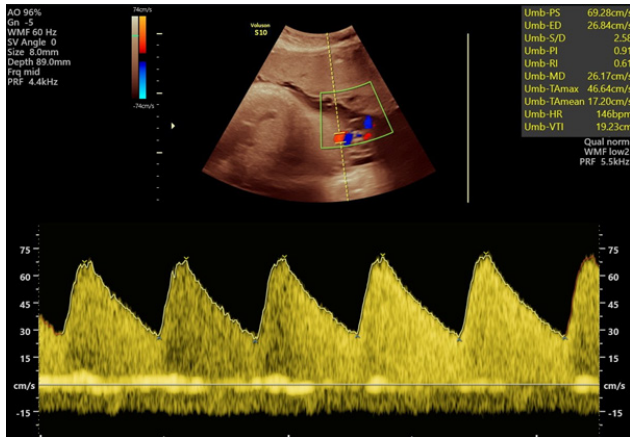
Normal umbilical artery Doppler with normal diastolic blood flow in 36 week gestation Umb-PI=0.91, Umb-RI=0.61
